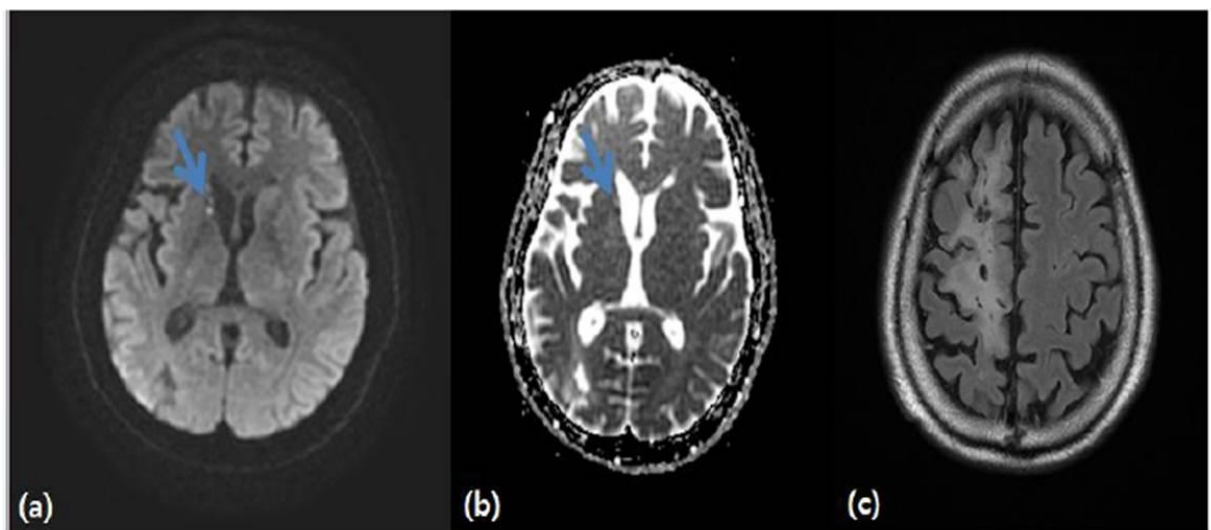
Brain MRI revealed tiny acute infarction in right basal ganglia (a,b). Brain MRI revealed old infarction with old hemorrhage in right fronto-parietal lobe (c). (a) Diffusion weighted images of the brain (b) Apparent diffusion coefficient images of the brain (c) T2 FLAIR image of the brain * FLAIR: fluid attenuated inversion recovery
